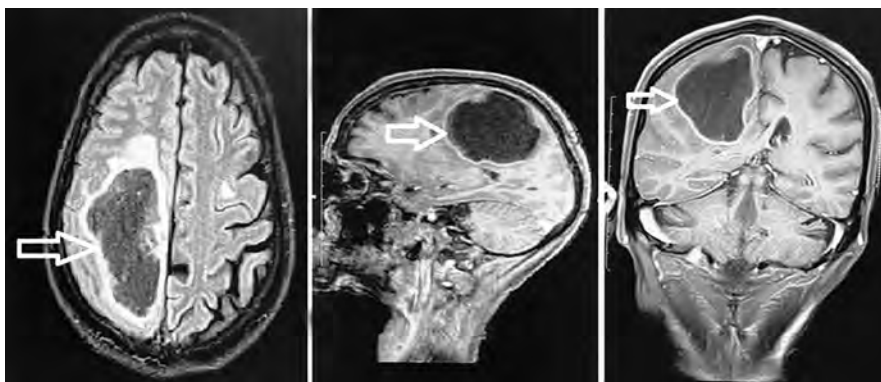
The MRI of the brain with T1, T2, and flair images were in favor of metastatic lesions in the brain
